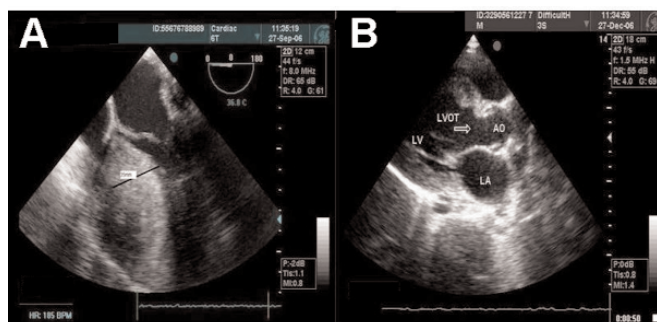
Transesophageal echocardiography (TEE). A, perioperative TEE image showing giant interventricular septum. B, postoperative TEE 3 months after surgery showing no obstruction on the left ventricular outflow tract TTE. LVOT indicates left ventricular outflow tract; AO, aorta; LA, left atrium.
